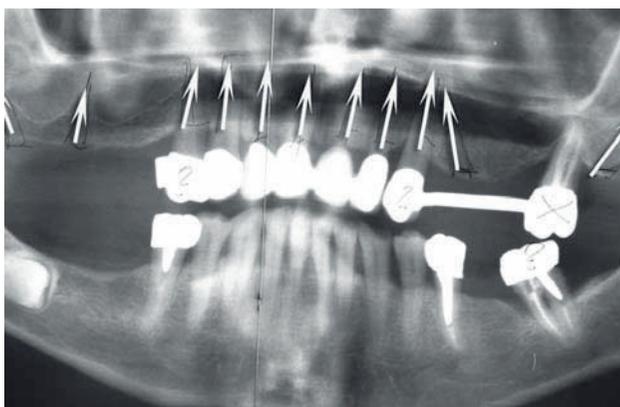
Diagnostic radiograph, five months prior to treatment.
